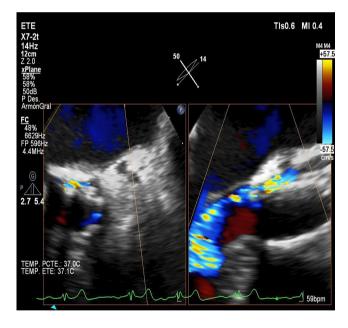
TEE X-plane color-Doppler image of the aortic prosthetic valve demonstrating severe PVL posteriorly located. TEE: transesophageal echocardiography. PVL: paravalvular leakage.
